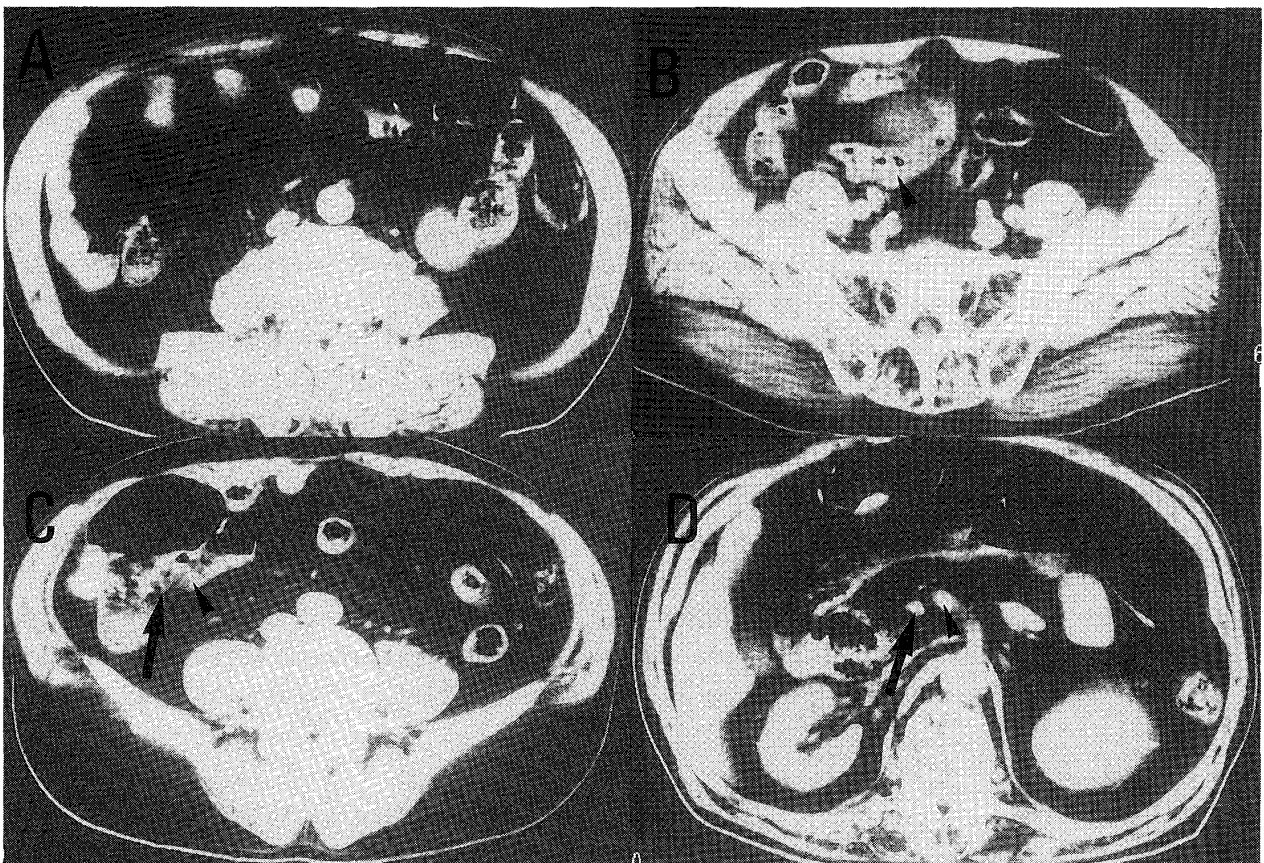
CT scans in case 1. (A) Gas-distended bowel in the anterior abdomen. (B) (C) Thumbprinting (arrow) and thickened (arrowhead) of the bowel wall. (D) A high density in the SMA (arrowhead) and a reduction in diameter of the superior mesenteric vein (arrow).
